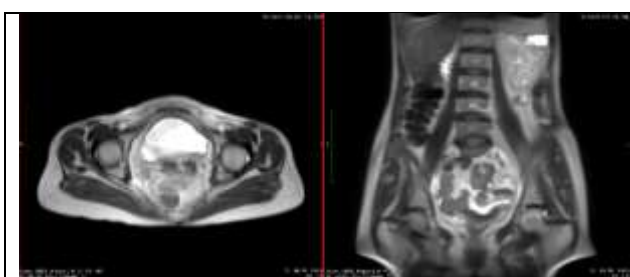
Post-Operative MRI Image of The Patient. Post Hysterectomy Status
